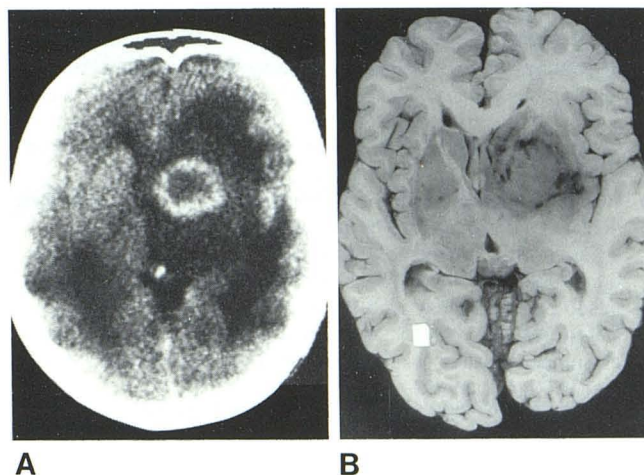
Case 2. CT presentation of toxoplasmosis lesions in patient with diagnosis of lupus erythematosus. A, 3-cm-diameter single-contrast enhancing ring lesion with central hypodense area and extensive surrounding edema in right basal ganglia. B, Corresponding area of granulomatous and necrotic tissues that contained *Toxoplasma* parasites.
